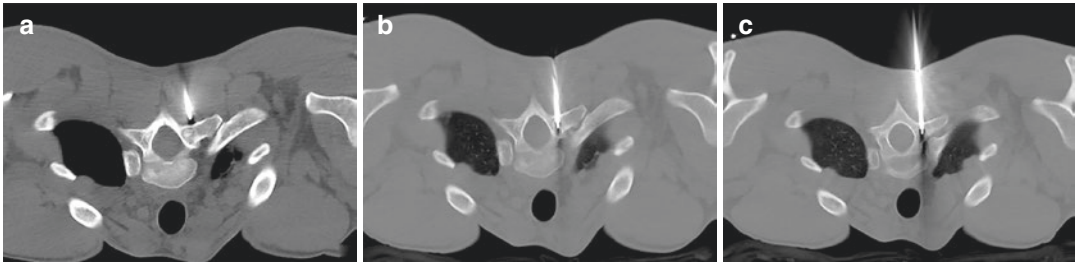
(a–c) Under CT guidance, working cannula and radiofrequency needle are positioned for the treatment of right T2 pedicle osteoid osteoma
